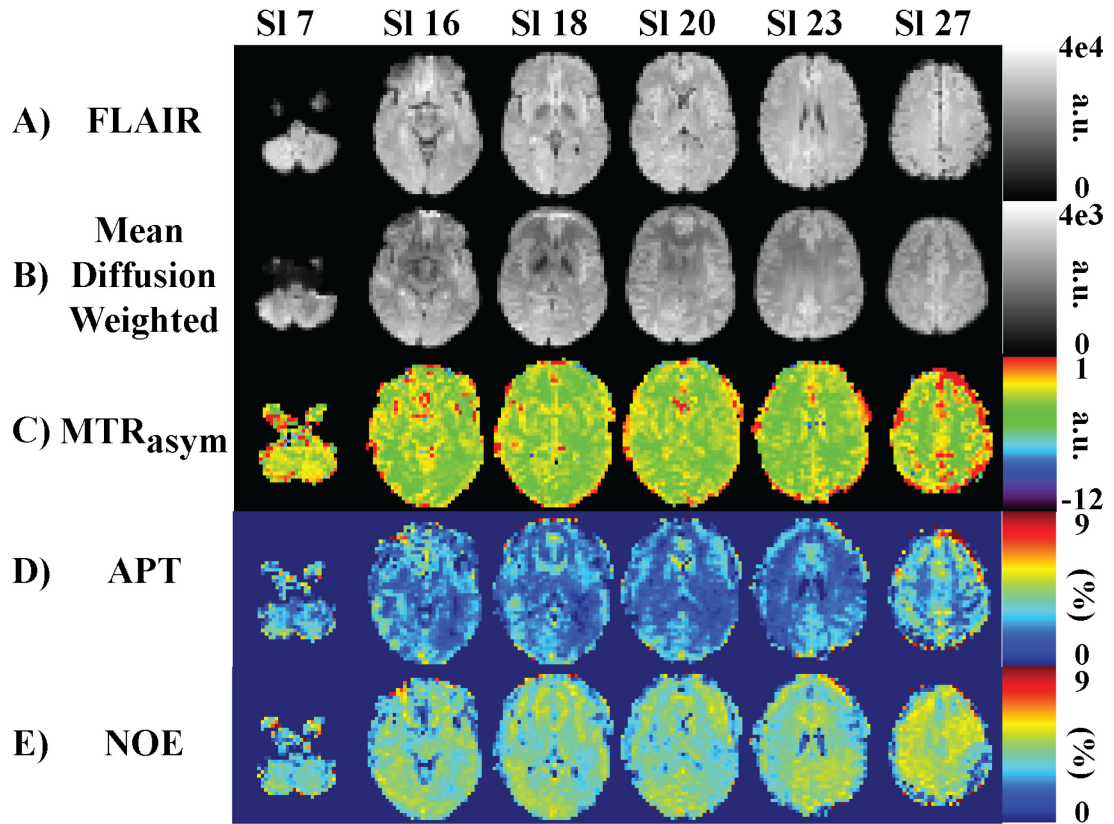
Data acquired on another healthy control subject. Select slices from the (A) FLAIR scan, (B) Mean Diffusion Weighted Image, (C)  $MTR_{asymmetry}(3.5 \text{ ppm})$  processed from the Steady State Pulsed CEST (pH-weighted), (D) APT processed from the Steady State Pulsed CEST scan, and (E) NOE processed from the Steady State Pulsed CEST scan.
